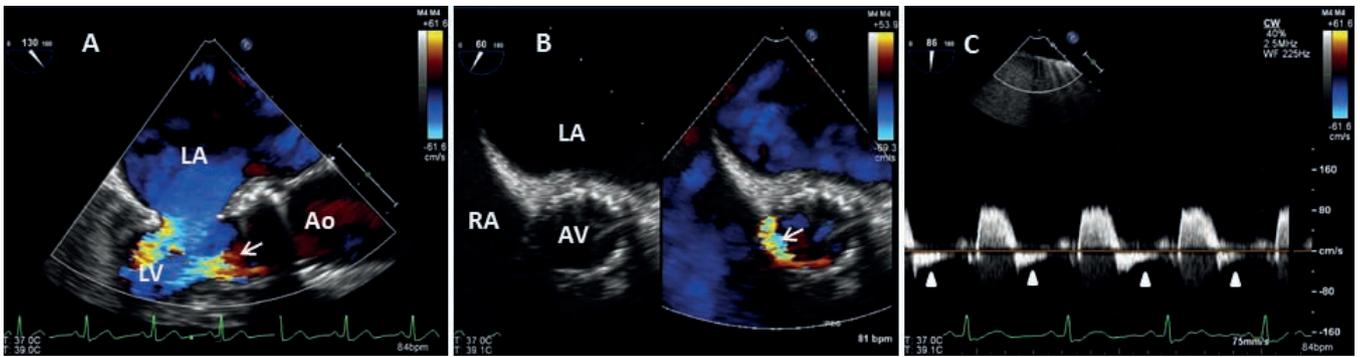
Severe paravalvular regurgitation after transcatheter aortic valve replacement. Transesophageal echocardiography performed immediately after valve deployment demonstrates severe paravalvular regurgitation (arrow) as seen on the long-axis view (A) which shows an eccentric jet. On the short-axis view (B) the two-dimensional image of the prosthetic valve ring is shown on the left; on the right, color Doppler shows the regurgitation jet (arrow) originating from around the valve on the anteroseptal territory consisting of > 20% of the valve ring, suggesting severe paravalvular regurgitation. (C) Flow reversal (arrowhead) is shown in the descending aorta, also consistent with severe aortic regurgitation. Ao, aorta; LA, left atrium; LV, left ventricle; RA, right atrium.
